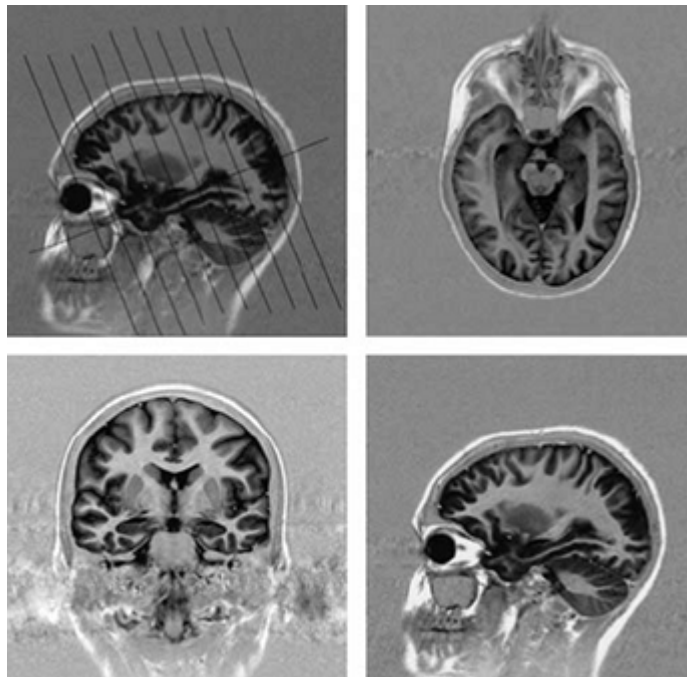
Epilepsy magnetic resonance imaging basics—the “hippocampal axis.” This image shows the basic orientation for an “epilepsy protocol.” The image sequence in this case gives axial and coronal images as shown. The whole of the hippocampus is seen in a single slice (top right), and there is little partial voluming of the hippocampus (lower left). Because the diagnosis of abnormalities in the mesial temporal region is fundamental to the assessment of any patient with epilepsy, this imaging plane must be part of any effective epilepsy protocol imaging.
